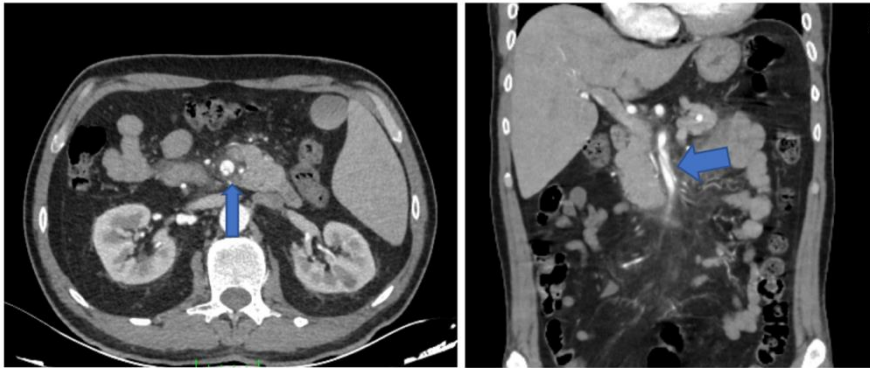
Axial CT showing intimal flap at proximal-middle SMA and sagittal/reformatted image -false lumen/true lumen distinction + jejunal branch occlusion.
